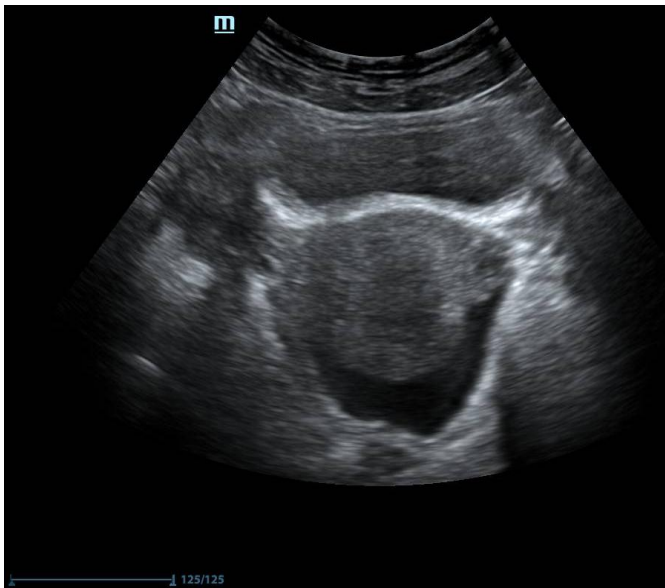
A transverse pelvic (transabdominal) grey scale ultrasound image showing fluid collection in the pouch of Douglas in a patient with pelvic inflammatory disease.
